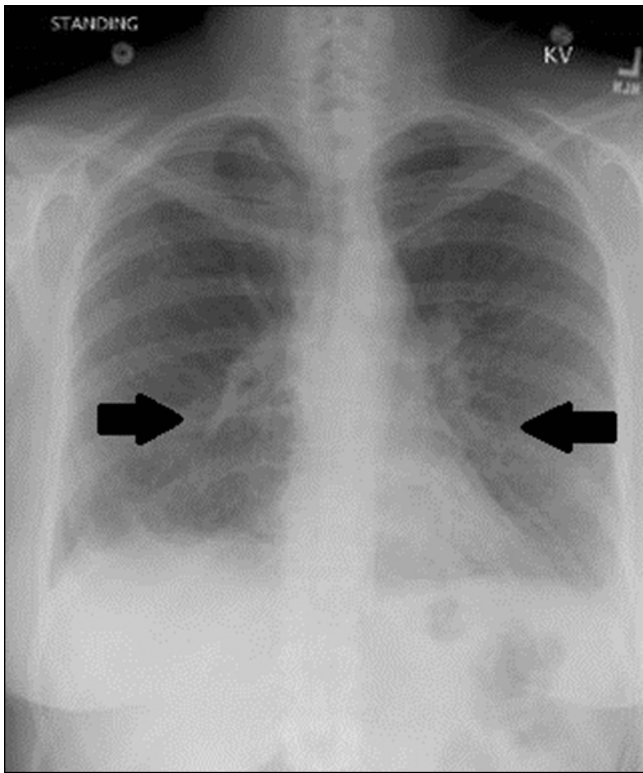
Chest radiograph demonstrating diffusely increased interstitial markings, bilateral hilar adenopathy, and a small left pleural effusion.
